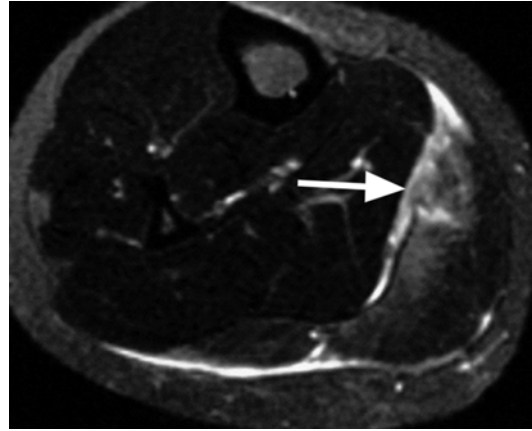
Moderate partial tear of the medial gastrocnemius muscle. Axial T2-weighted fat-suppressed image shows diffuse high-signal-intensity changes which involve more than a muscle fascicle/bundle (*arrow*)
